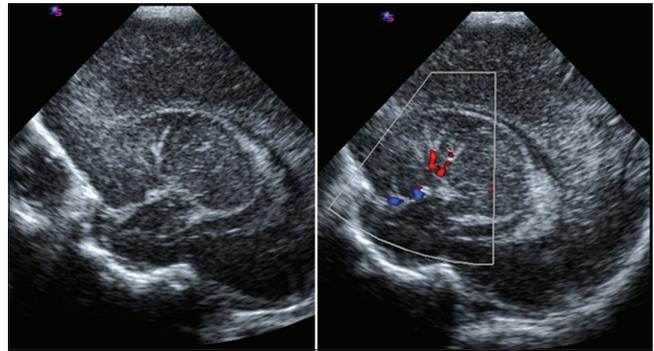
Parasagittal images demonstrating patchy areas of calcification in the branches of middle cerebral artery. Corresponding Doppler image showing patent vessels with wall calcification
